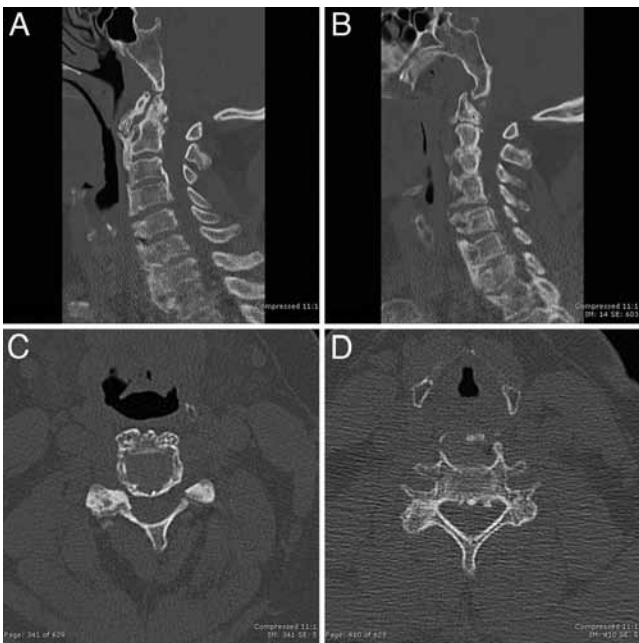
Admission CT scans of the cervical spine in sagittal (A and B) and axial (C and D) projections demonstrate OPLL bridging the C3–5 disc space and posterior to the C-5 VB.
